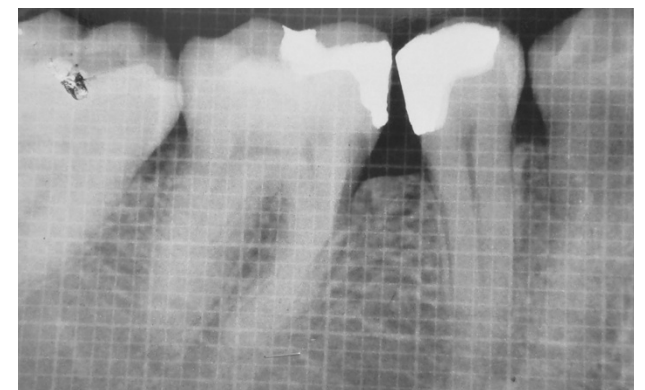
(f). X-Ray with Grid at 6 months
